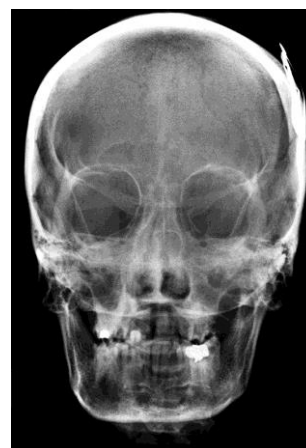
A Caldwell radiograph showing opacification of frontal and ethmoidal sinuses.
